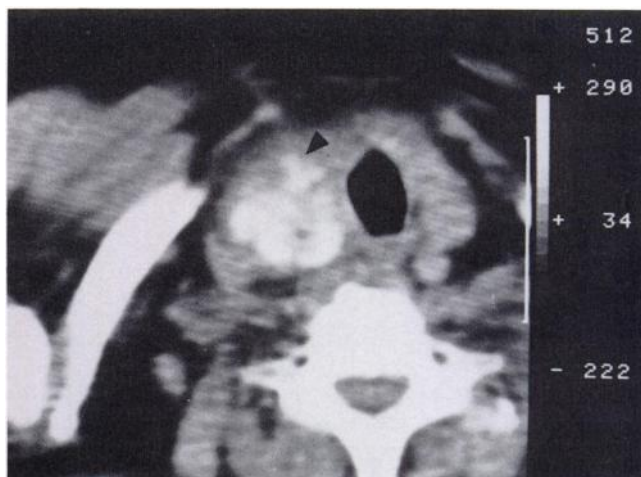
CT scan (without intravenous contrast) showing slight deviation of the trachea to the left and extensive calcification throughout the tumor.
